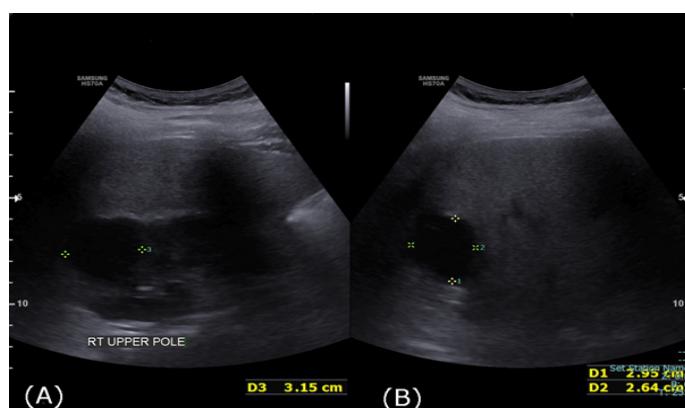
and 4B : Show a repeat ultrasound at day-14 after admission revealing a right upper pole cystic lesion had become smaller in size. CT
